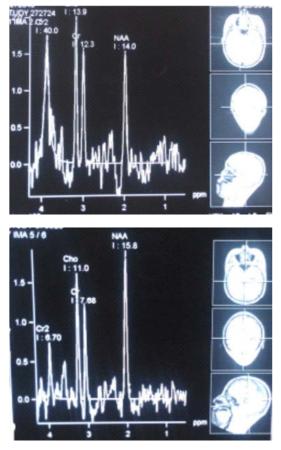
Imaging findings of a 21-year-old patient with epilepsy prior to and after treatment. The patient suffered from complex partial seizure complicated by GTCS seizures for 7 years. EEG image shows left temporal discharge and MRI displays left HS. The patient orally took CBZ(0.6 g/d). Prior to treatment, NAA/(Cr +Cho) value was 0.53. After treatment, NAA value was increased, and Cho, Cr values were decreased, so the NAA/(Cr +Cho) value was 0.84.
